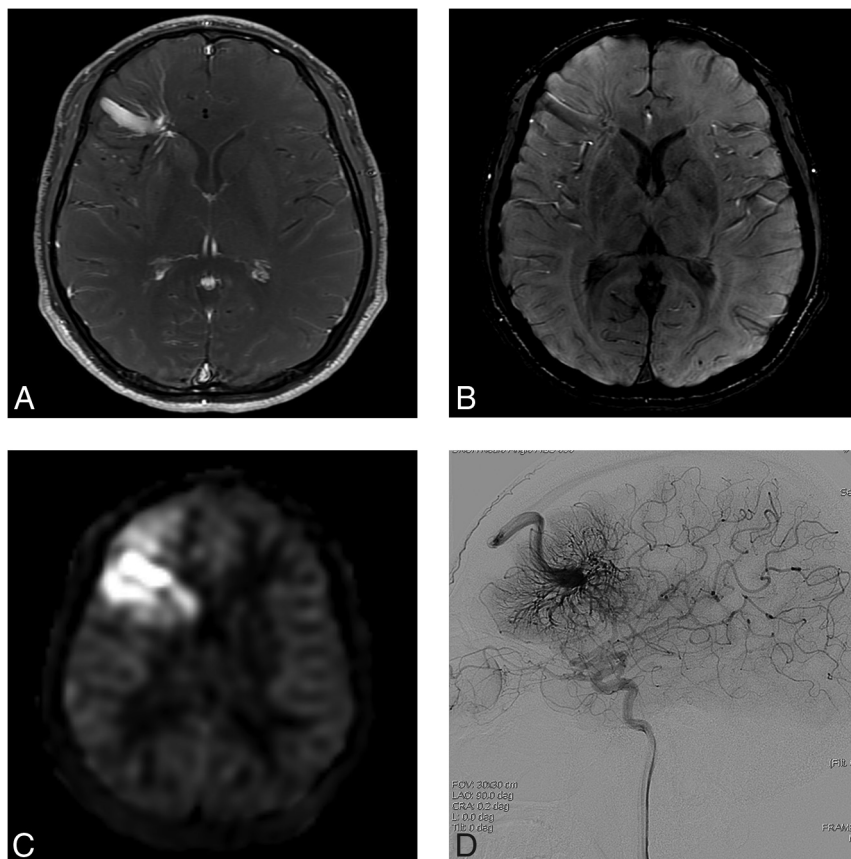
A 31-year-old man presenting with dizziness (case 4). A, Contrast-enhanced T1-weighted axial MR imaging shows a DVA-like lesion in the left frontal lobe. B, On SWI, both hyperintense and hypointense signal is present in the collecting vein, while only hypointense signal is present in the dilated medullary veins. C, The ASL quantitative CBF image demonstrates hyperintense signal intensity in the collecting vein and parenchyma corresponding to the location of the lesion, suggesting a vpAVM. D, On DSA, a caput medusae appearance of medullary veins draining to the superior sagittal sinus via a collecting cortical vein is visualized in the arterial phase.
